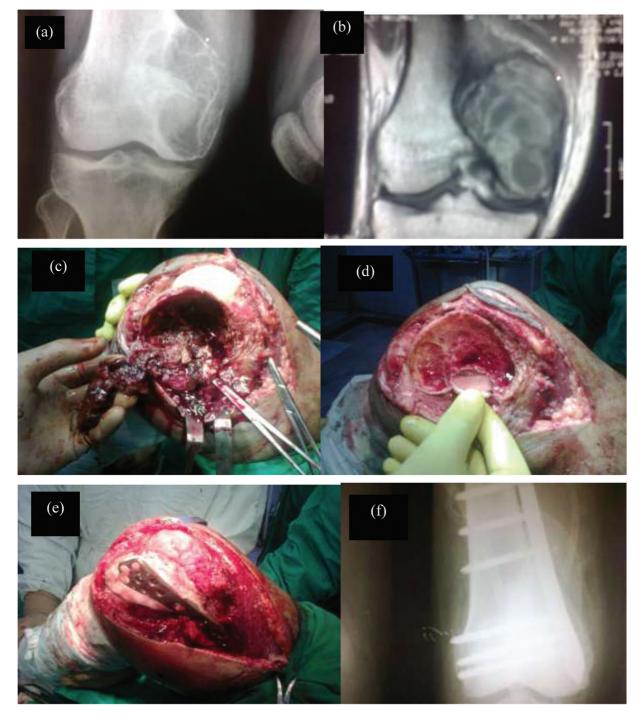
Surgical technique for extended curettage of GCT of the distal femur showing (a) preoperative X-ray (b) preoperative MRI (c) creation of cortical bone window and curettage of contents (d) after burring and washing with hydrogen peroxide and saline (e) filling the cavity with bone allograft, bone cement, and fixing with LCP (f) postoperative X-ray.
